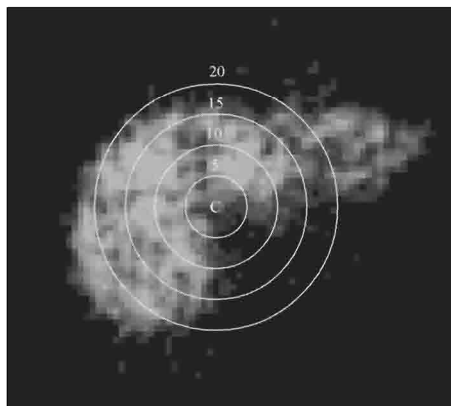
A transverse reconstructed SPECT slice with the different sampling radii centred on the confluence of the right and left hepatic ducts (C)
